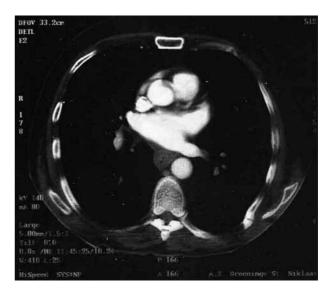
Computed tomography of the chest showed a thickening of the distal oesophageal wall with stenosis. There were no adenopathies or other signs of malignancy.
